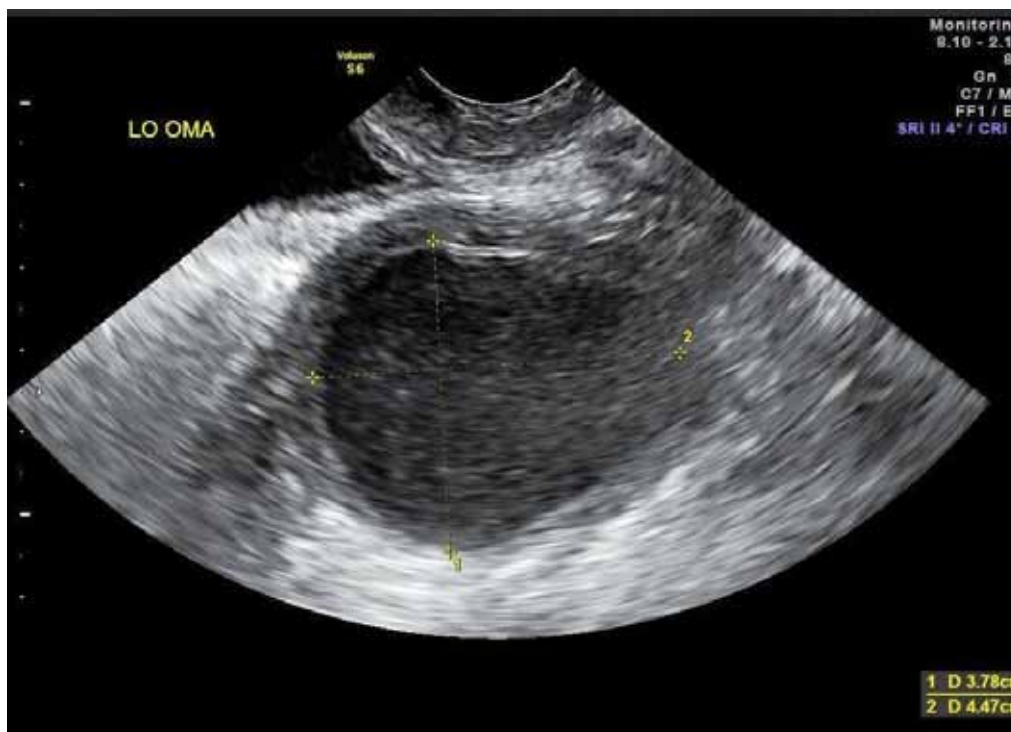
Transvaginal ultrasound. Endometriomas contain old brown blood, which is why they have been referred to as “chocolate cysts.” On transvaginal ultrasound, endometriomas often display a characteristic ground glass appearance.
